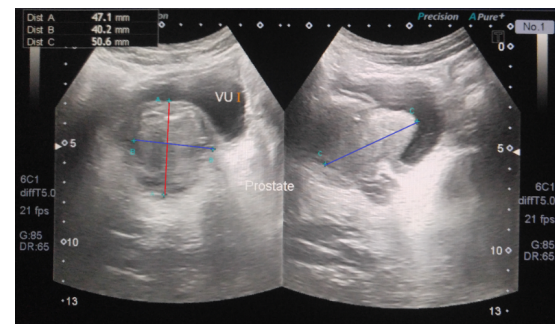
Prostate ultrasound image
